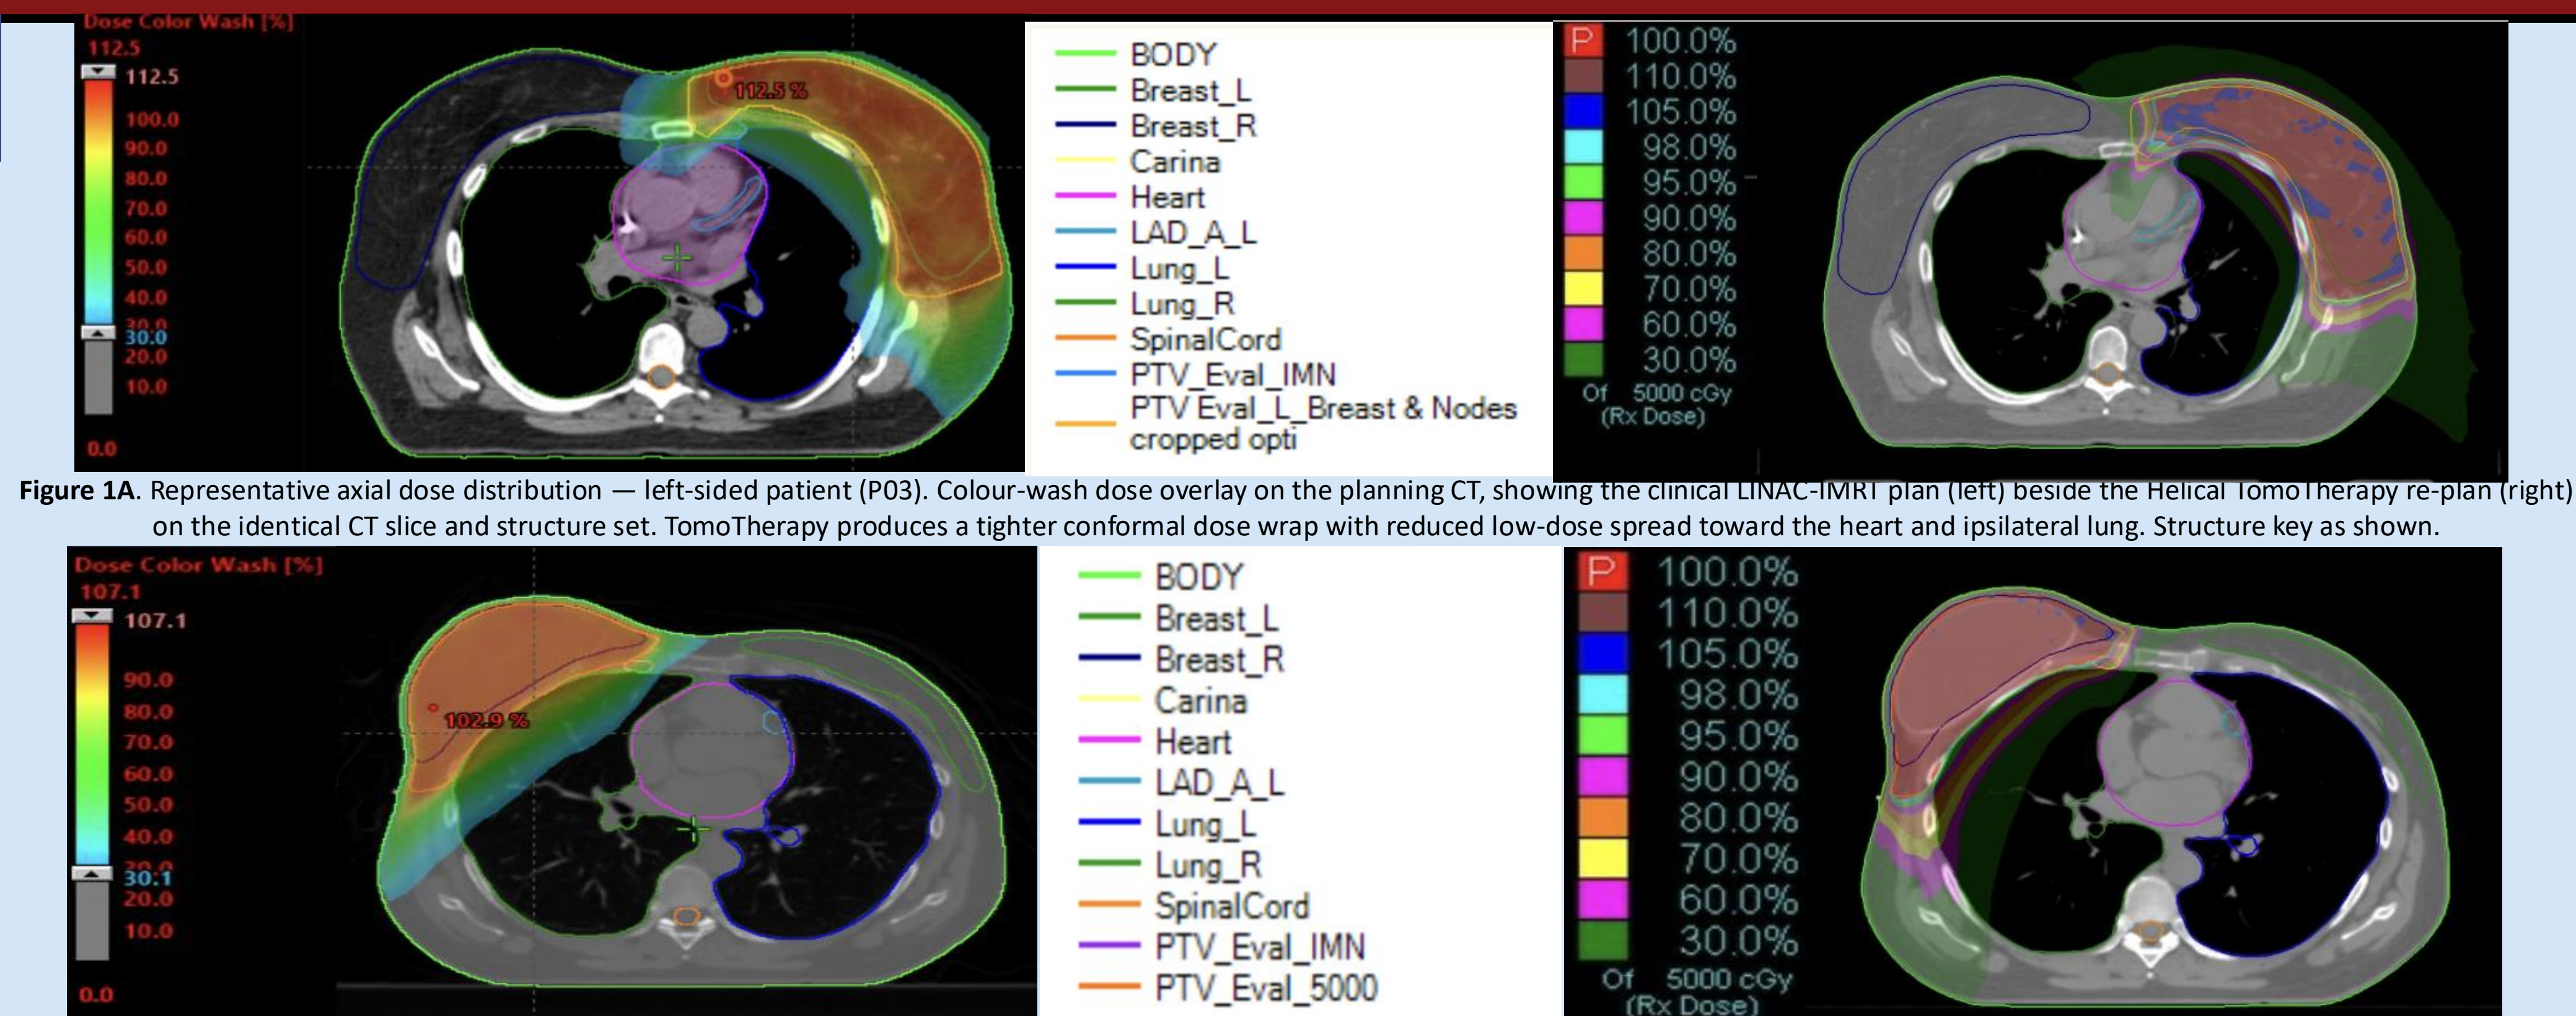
Representative axial dose distribution — left-sided patient (P03). Colour-wash dose overlay on the planning CT, showing the clinical LINAC-IMRT plan (left) beside the Helical TomoTherapy re-plan (right) on the identical CT slice and structure set. TomoTherapy produces a tighter conformal dose wrap with reduced low-dose spread toward the heart and ipsilateral lung. Structure key as shown.
